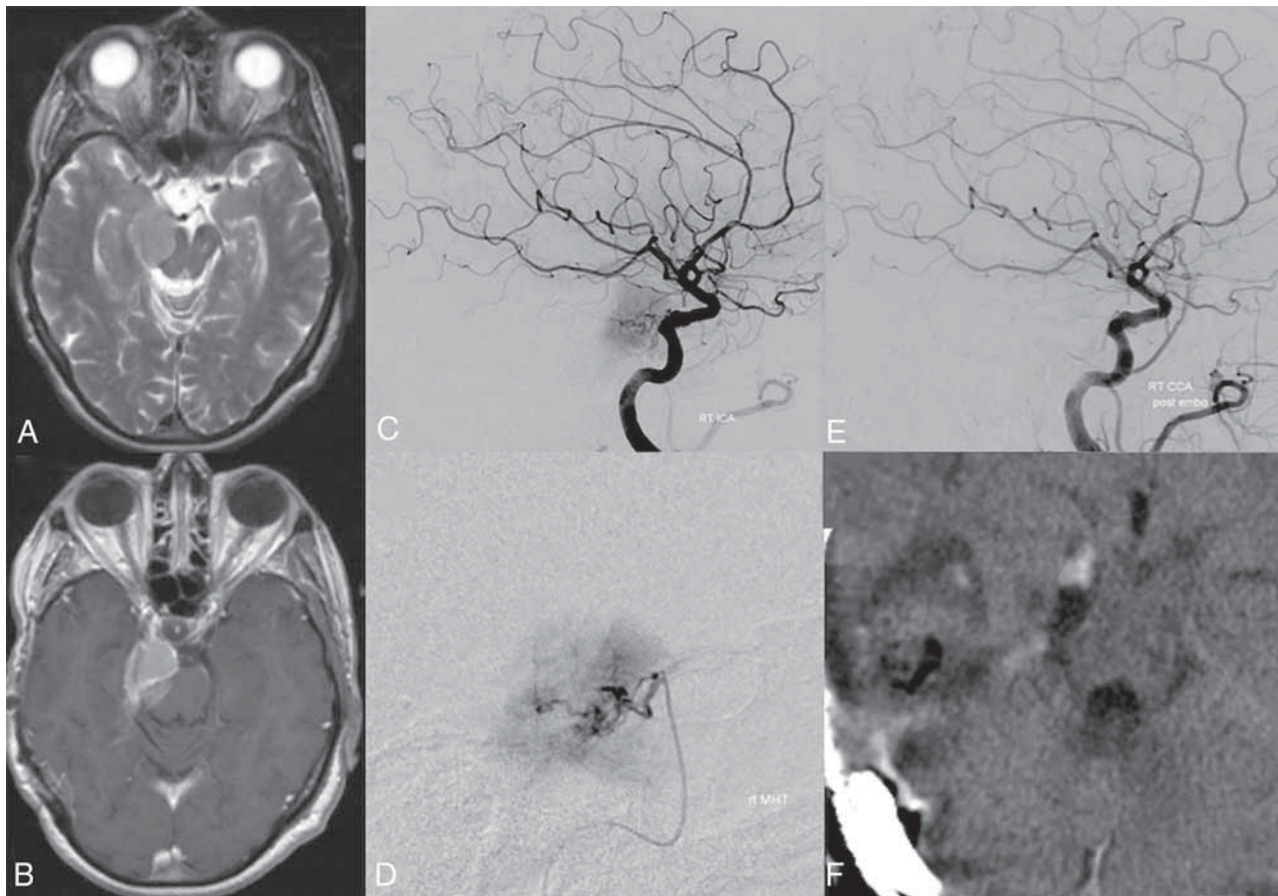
A patient with a right petroclival meningioma as shown on MR imaging T2 (A) and postcontrast T1 (B). A right ICA injection lateral view DSA (C) demonstrates a large blush supplied by the meningohipophyseal trunk. Selective catheterization and DSA (D) with a Marathon microcatheter (Medtronic), followed by embolization with 45- to 150- and 150- to 250- μ m particles. Final right ICA injection, lateral view DSA (E) demonstrates resolution of the previously seen blush. Final CT (F) postsurgical resection demonstrates complete excision with a small amount of retraction injury in the right temporal lobe.
